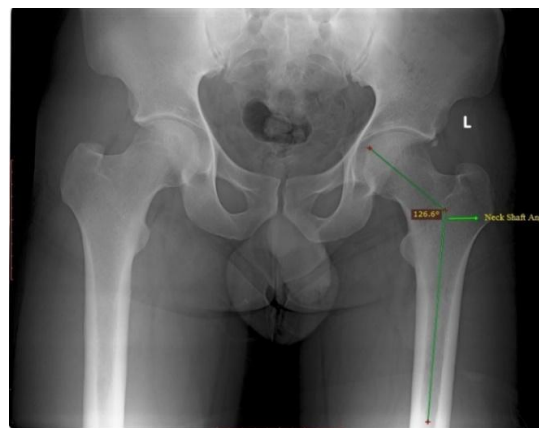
Sagittal X-ray of Hip showing Neck Shaft Angle
